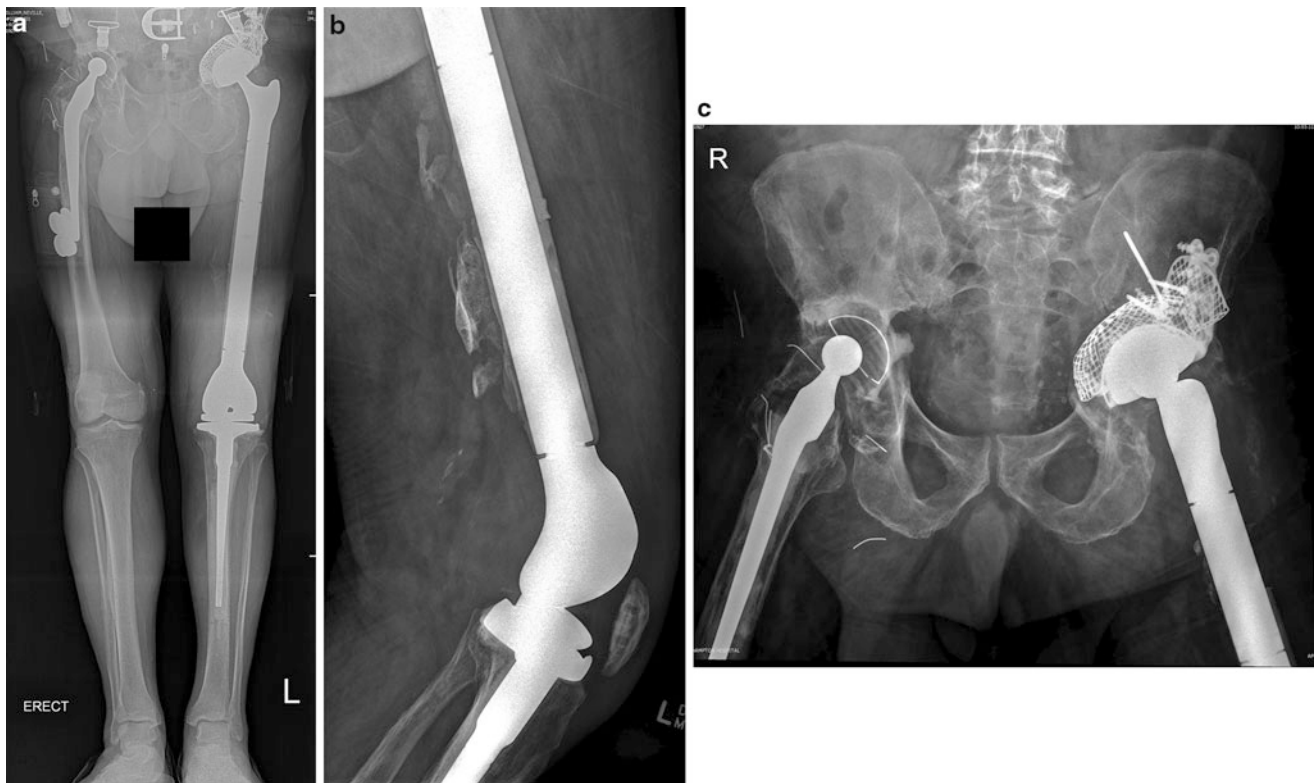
(a, b and c) Postoperative radiographs after the second stage, conversion to a total femur mega-prosthesis
